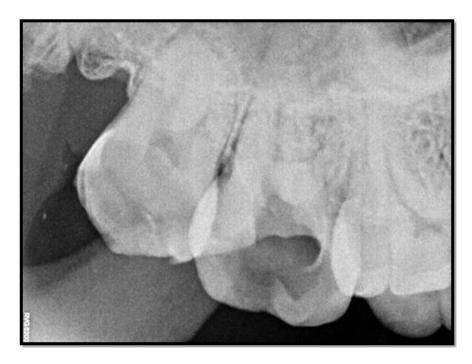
(Preoperative radiograph of right maxillary second molar.)
